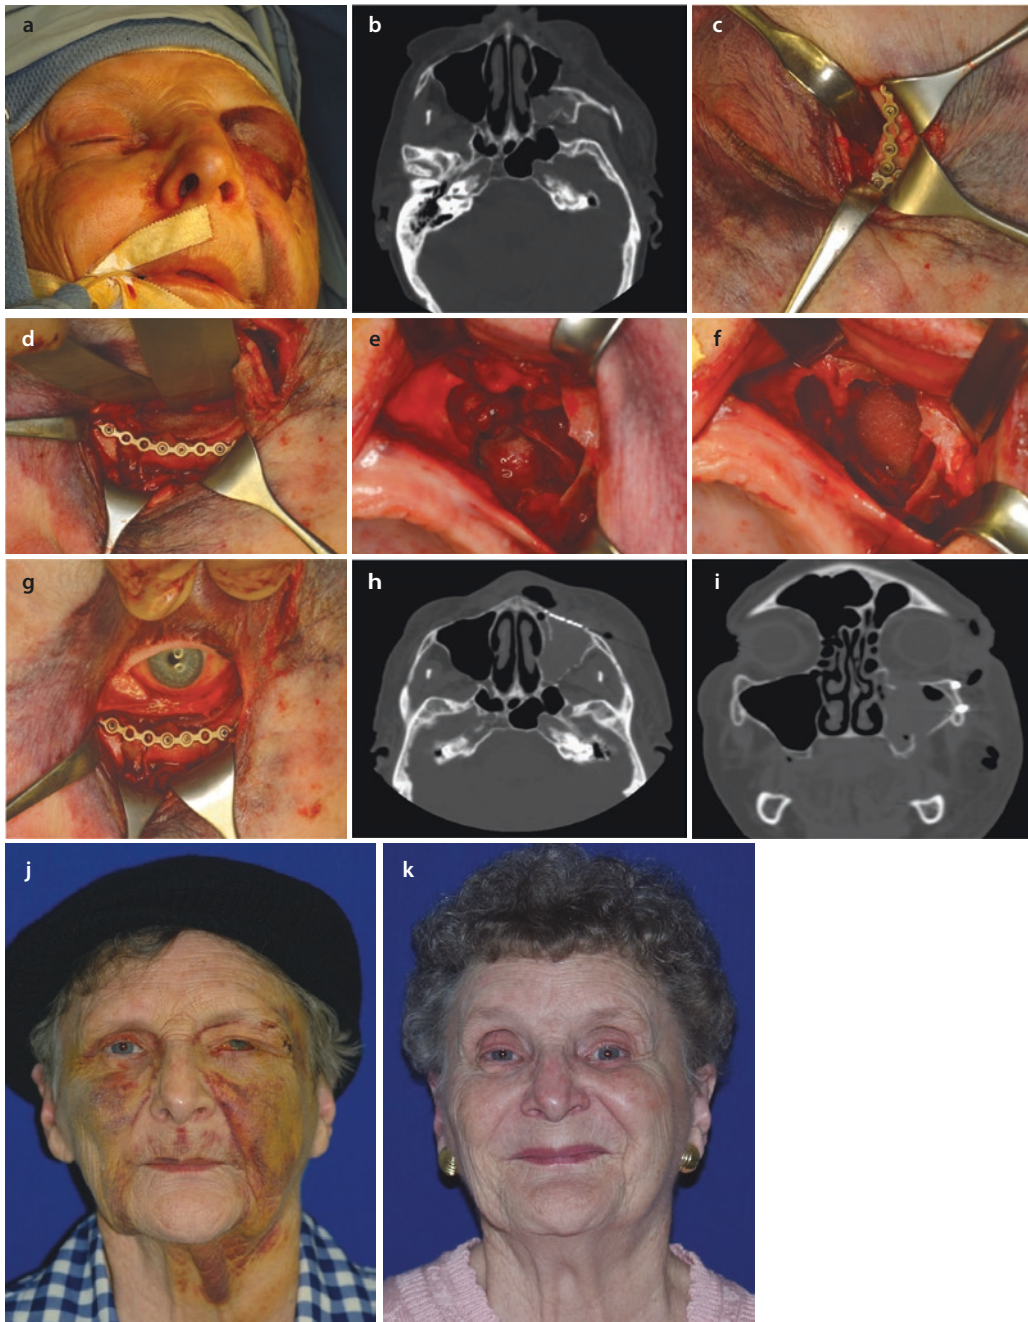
a An elderly female sustained a severely displaced left zygomatic complex (ZMC) fracture with >75% orbital floor disruption. She was on warfarin sodium and had moderately decreased left visual acuity with increased ocular pressures. b Axial CT scan revealed a ZMC fracture with a severe posterior, medial, and moderate inferior displacement. c The patient was taken urgently (within 12 h) for surgical treatment to reduce the fracture and re-expand the orbital volume. Serial examination and ocular pressure checks were performed every 2 hours pre- and postoperatively. Owing to cardiac risk factors, the anticoagulation was not reversed nor was the patient treated with fresh frozen plasma. The zygomaticofrontal (ZF) suture area was first approached through a lateral brow incision. After the intraoral vestibular and then transconjunctival approaches were accomplished, the ZF fracture was plated. d The infraorbital rim was fixated with a 1.2 mm titanium plate, and the floor was reconstructed with 0.85 mm porous polyethylene sheeting. e The left maxillary sinus anterior wall defect visualized through the vestibular incision
